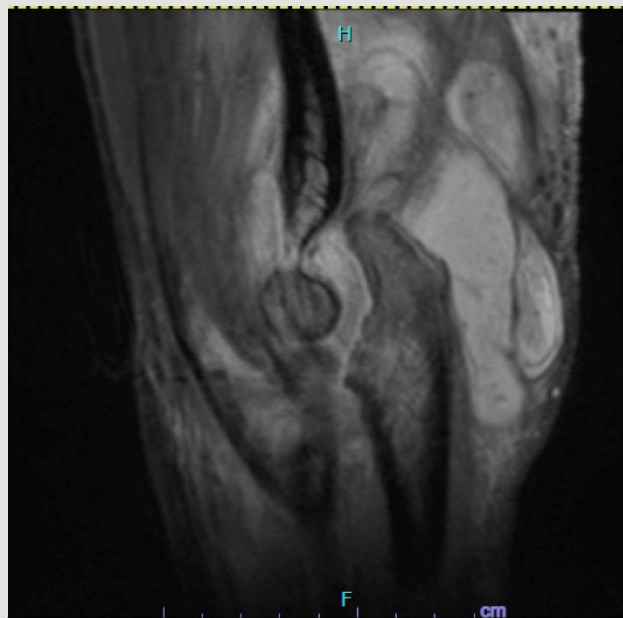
Sagittal proton density fat suppressed magnetic resonance imaging scan of the elbow demonstrating destructive changes of the coronoid with extensive
